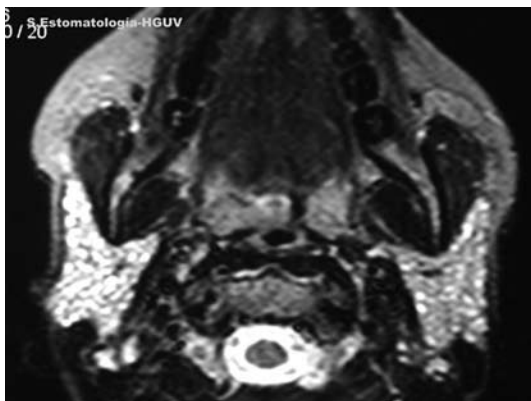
Magnetic resonance imaging view showing a heterogeneous, nodular or honeycomb pattern in both parotid glands.
